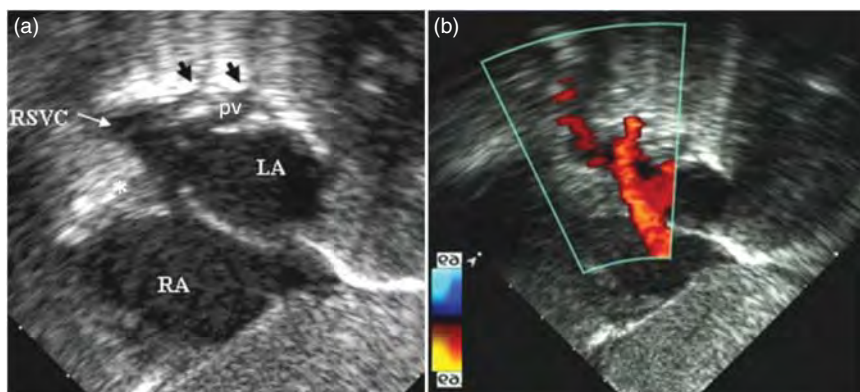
Two-dimensional echocardiography. (a) Right superior vena cava (RSVC) connected to the left atrium (LA). (b) Left-to-right shunting across the non-restrictive secundum atrial septal defect and flow from the right pulmonary veins (pv) into the RSVC. Source: Vassallo *et al.* 2006 [13]. Reproduced with permission of John Wiley & Sons.
